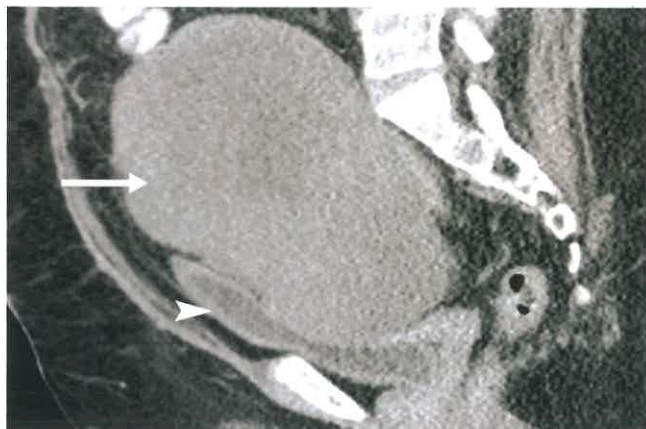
Ovarian Fibroma. Sagittal reformatted image from a CT scan demonstrates a very large lobulated homogeneous solid mass (arrow) arising from the pelvis and compressing the bladder (arrowhead). The patient had small pleural effusions and ascites that resolved after resection of the benign ovarian fibromas.
